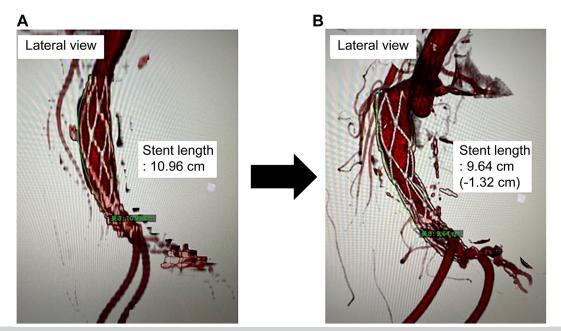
Three-dimensional computed tomography lateral view of patient 1. A, Postoperative day 3. B, Five years later.
